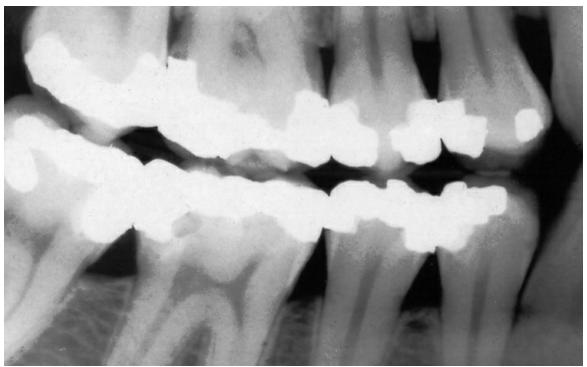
A traditional two-dimensional dental radiograph showing the hard tissues of the teeth, containing metallic amalgam restorations, and the supporting alveolar bone.
